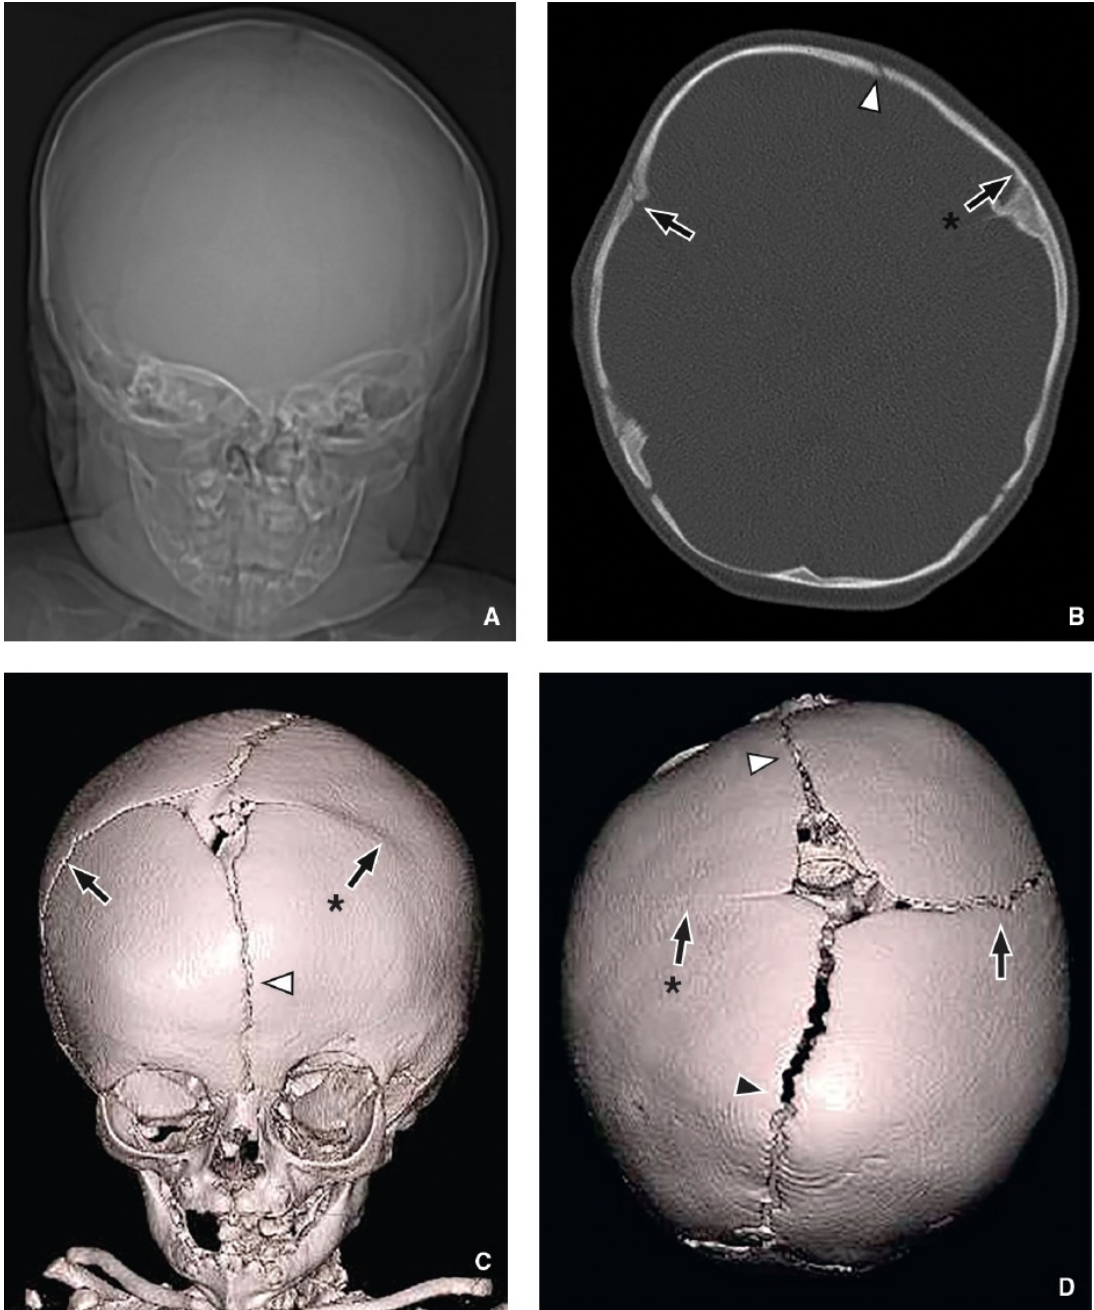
Unilateral coronal synostosis in a 4-month-old boy with abnormal head shape. A: Frontal projection CT topogram demonstrates elevation of the left orbital rim. B: Axial bone window CT image demonstrates premature fusion of the left coronal suture (abnormal side *asterisked arrow*). C and D: Three-dimensional surface rendering CT images in the frontal (C) and superior (D) perspective demonstrate left frontal plagiocephaly and right frontal bossing with retraction of the metopic suture to the left. Labeling conventions as for [Figure 1.2](#) with abnormally fused left coronal suture denoted by an *asterisked black arrow*.
